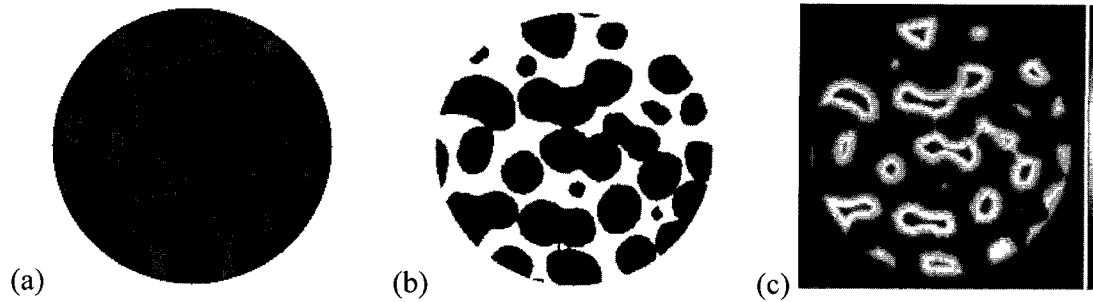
2-D representative of (a) original μ CT image, (b) binary image and (c) DT map.
